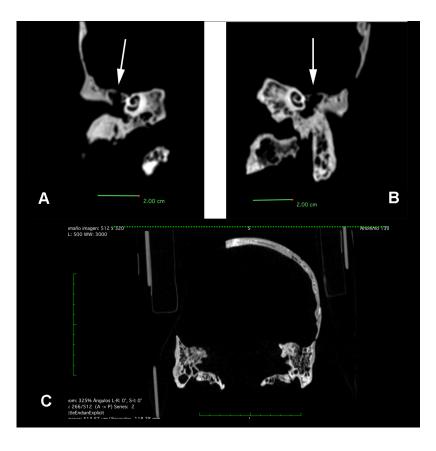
Computer Tomography: Coronal CT of the middle ear showing the perforation of the *Tegmen tympani* and the healthy appearance of the cochlea on both the right (A) and left (B) *os temporale*. The arrows point to the lesion. C: Coronal CT of the mastoid process showing normal morphology of the mastoid air cells.
